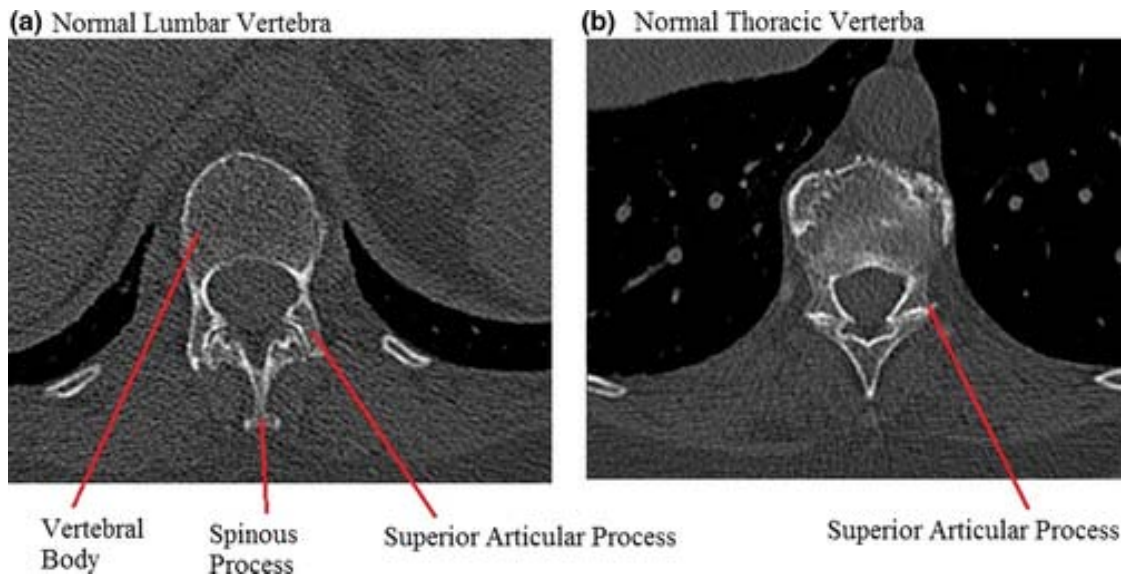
CT scan of a normal thoracic (a) and normal lumbar vertebrae (b) demonstrating superior facet orientation and symmetry
